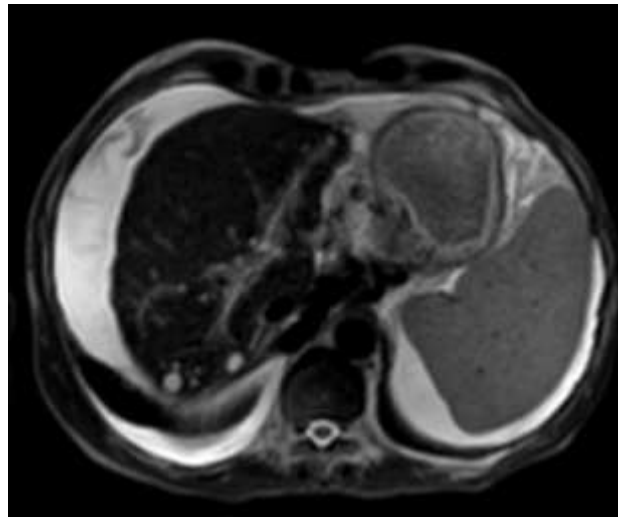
MRI Abdomen showing portal hypertension features with ascites, liver nodularity, splenomegaly, portosystemic collaterals
